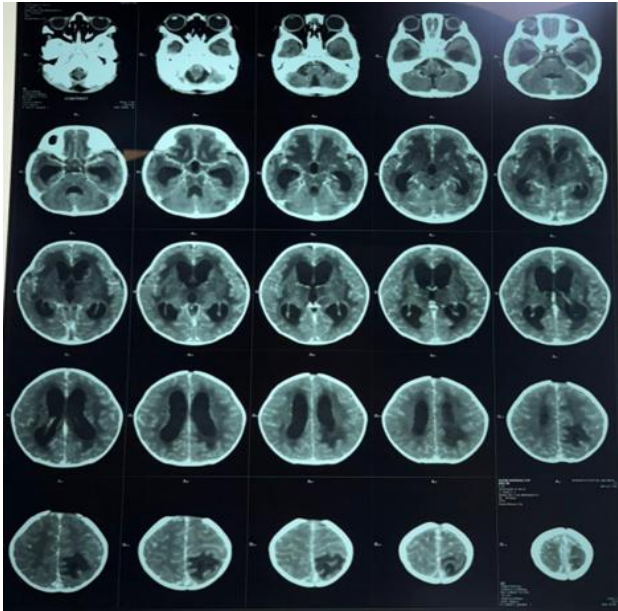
Contrast-enhanced axial CT brain showing basal meningeal enhancement in the basal cisterns, characteristics of tuberculous meningitis.
